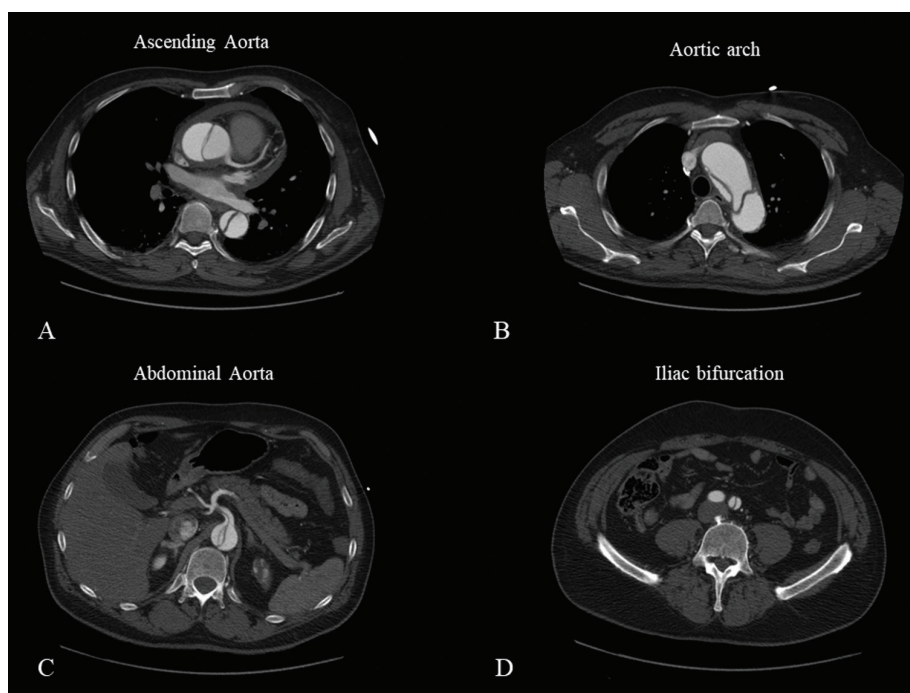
CT scan: Dissection of the thoracic (A – B) and abdominal aorta (C) from the aortic bulb to the left iliac artery (D).
